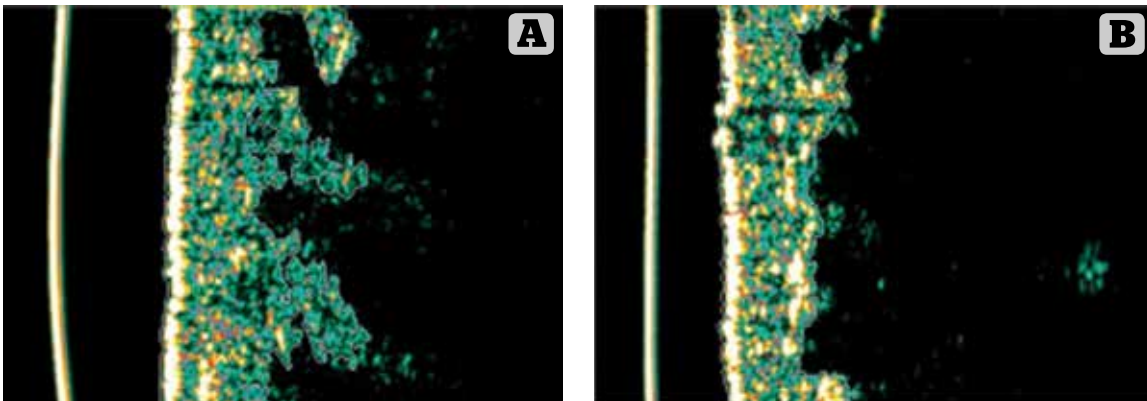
High resolution ultrasound images with a height of 12.1 mm and a penetration depth of a few cm of the skin obtained at the front side of the right thigh. (A) Image at baseline. The long contour line resulting from the dark notches that penetrate into the epidermis is clearly visible. This is a manifestation of cellulite. (B) The dark notches are drastically reduced at the follow-up visit
